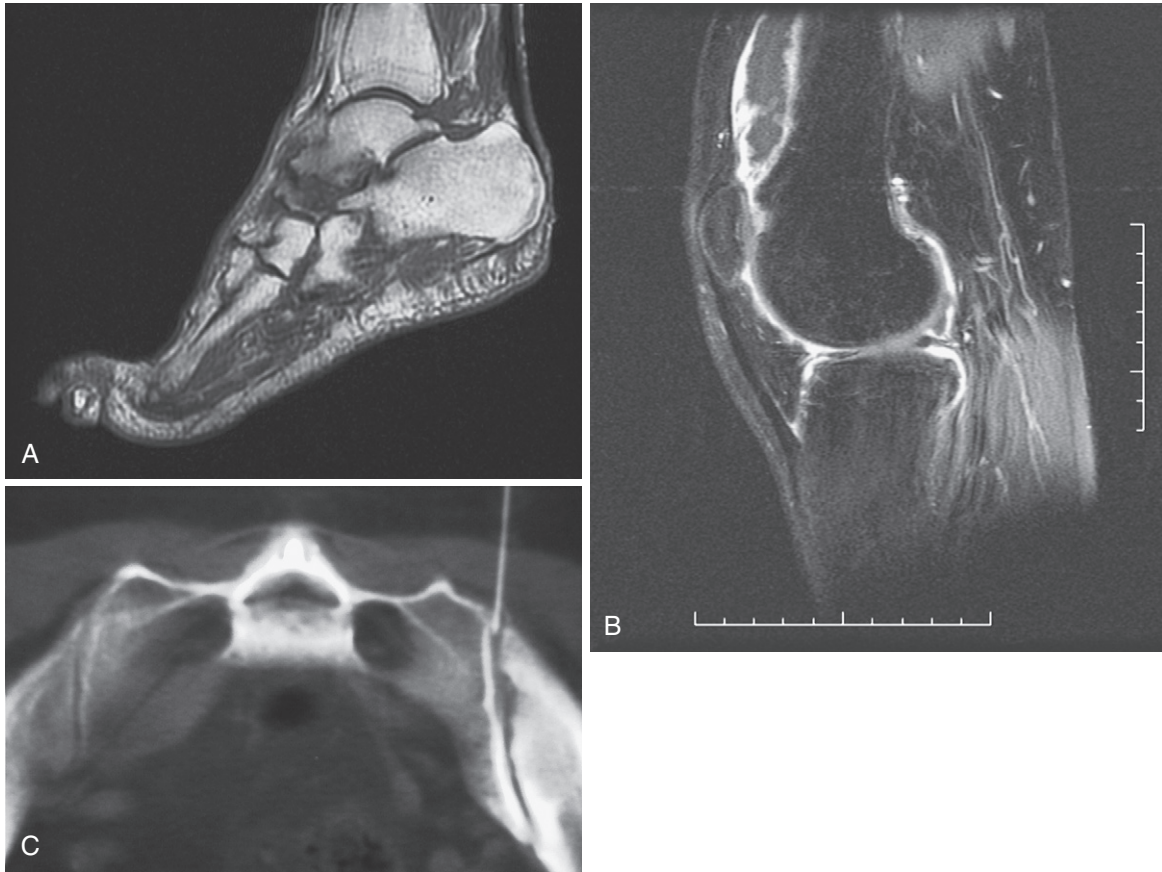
A, T1-weighted magnetic resonance imaging (MRI) of left foot confirming severe talonavicular disease with bone edema. B, Contrast-enhanced MRI of an inflamed knee joint in psoriatic arthritis showing synovial enhancement and large suprapatellar effusion. C, Computed tomography scan of sacroiliac joint showing sclerosis, erosion, and needle in place just before corticosteroid injection. (Courtesy Dr. Robin Gibney.)
